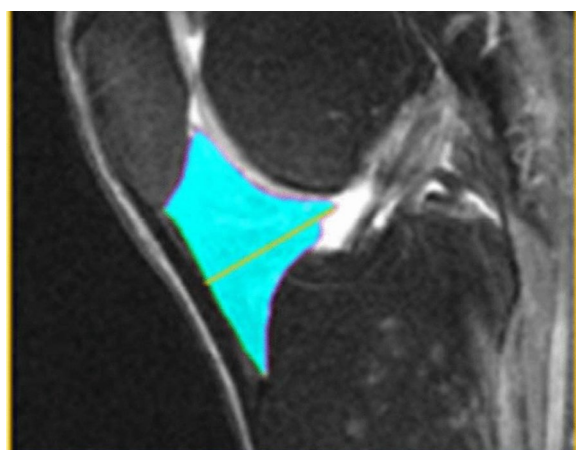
Measurement of IPFP sagittal thickness (for this figure, all the authors Giovanni Ricatti, Nicola Veronese, Ilaria Gangai, Mariateresa Paparella, Valentina Testini, Giuseppe Guglielmi have given the permission to publish this figure for both the print and online format. This figure is present in the article Ricatti G, Veronese N, Gangai I, Paparella M, Testini V, Guglielmi G. Hoffa’s fat pad thickness: a measurement method with sagittal MRI sequences. Radiol Med. 2021 Jun;126(6):886–893. <https://doi.org/10.1007/s11547-021-01345-9>. Epub 2021 Mar 27. PMID: 33,772,711; PMCID: PMC8154775
